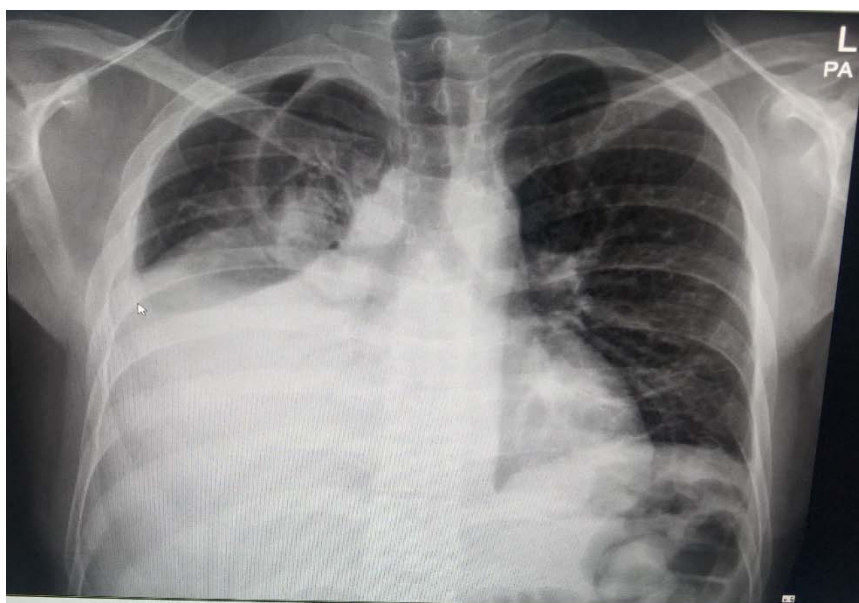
Chest X-Ray Left side Massive Hemothorax
